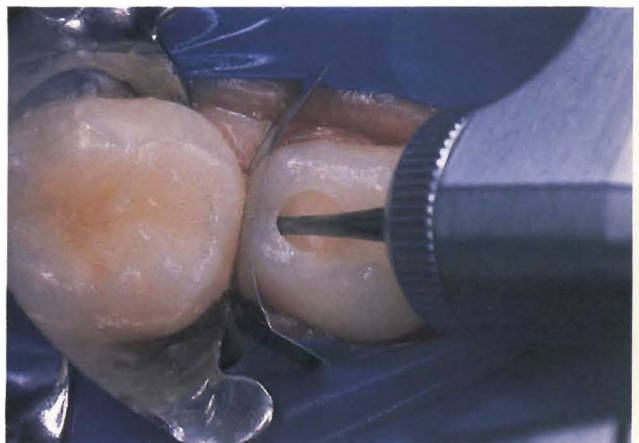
After judging the position of the carious lesion on the bitewing radiograph, a suitable round bur at slow speed was used to carefully probe for the lesion. Care was taken to avoid penetration of the pulp space.
